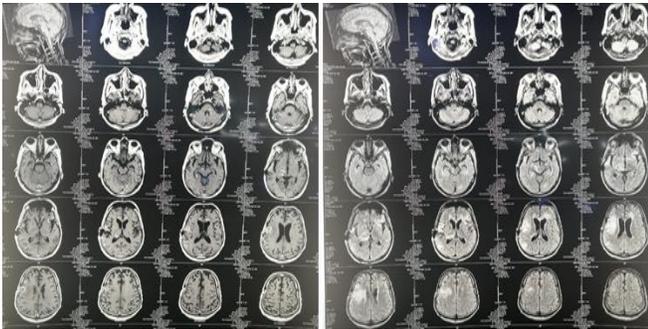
MRI brain repeated 6 weeks later.
